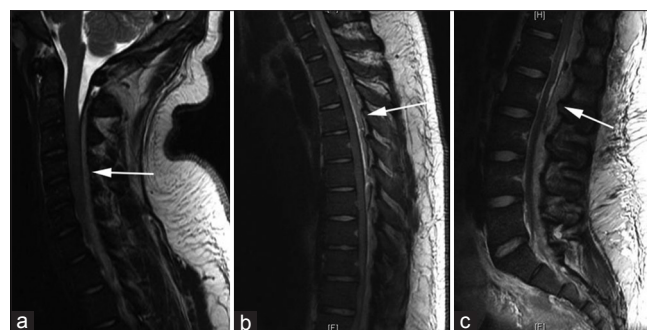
Sagittal T2-weighted magnetic resonance imaging (MRI) scan depicting spinal epidural abscess compressing the cervical cord posteriorly with blockage of cerebrospinal fluid flow (a). Sagittal T2-weighted MRI scan demonstrating spinal epidural abscess extending down the thoracic (b), and lumbar (c) vertebrae compressing the cord posteriorly
